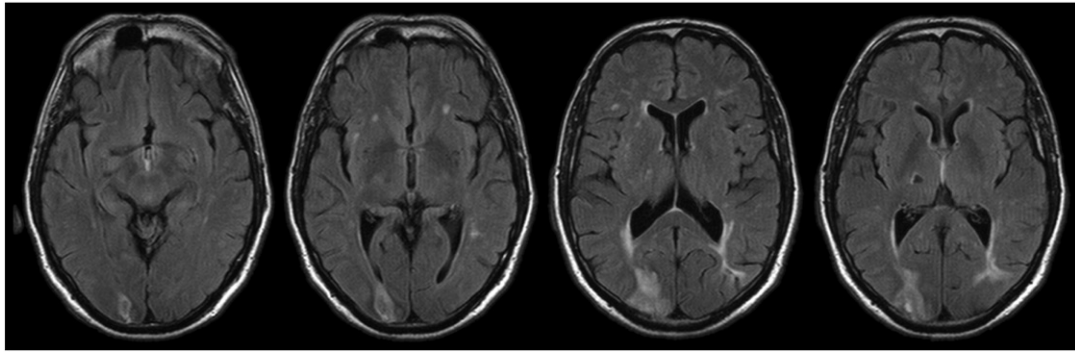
Axial images of the lesion of CQ (T1 weighted MRI). The left side of each slice represents the right side of the brain, and the images proceed from ventral slices on the left to dorsal slices on the right.
